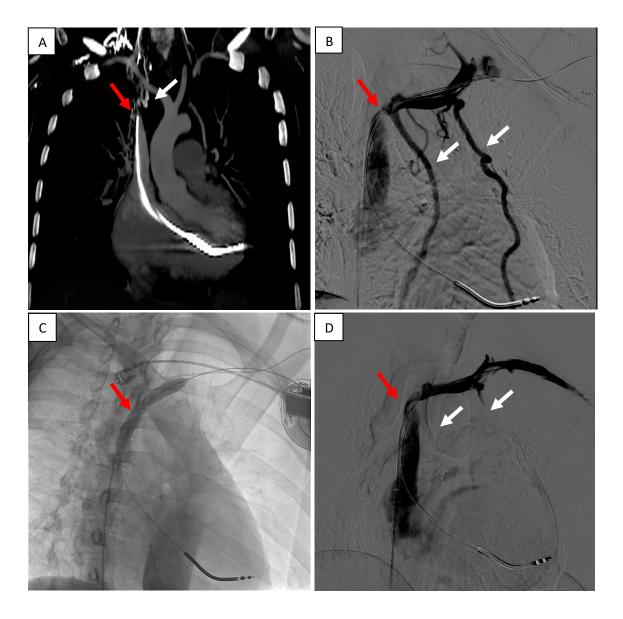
A. Computed tomography angiography showing obstructed right brachiocephalic vein and subtotal occlusion of superior vena cava (SVC; red arrow) with visible collateral circulation (white arrow); B. Digital subtraction angiography (DSA) showing critical stenosis of SVC (red arrow) with visible collateral circulation (white arrows); C. Percutaneous transluminal angioplasty using the EverCross Balloon Catheter (8×60 mm, 10 atm, Medtronic); D. Control DSA showing normal outflow from the SVC, with no flow *via* collateral circulation (white arrow)
